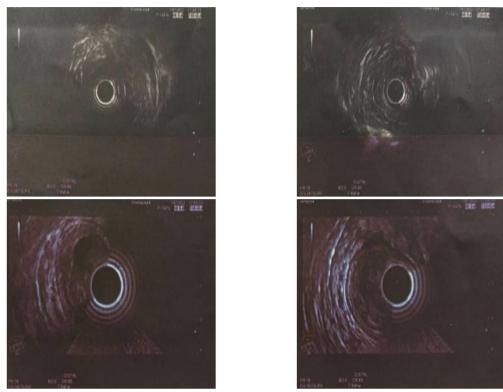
Endo-ultrasonographic view: Subepithelial lesion from muscularis mucosa layer
